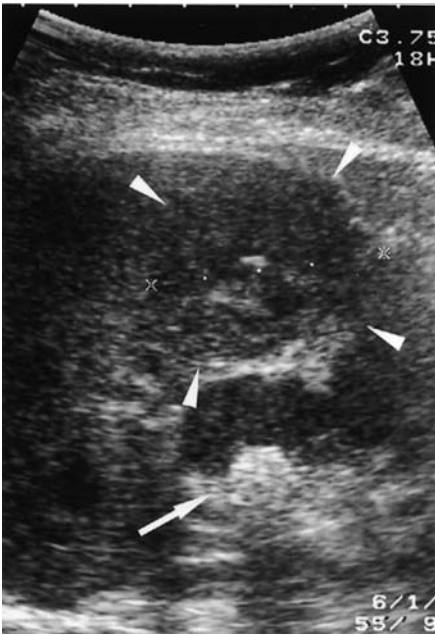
Abdominal ultrasonography (US), showing a 14-mm gallstone (*arrow*), and a heterogeneously hypoechoic mass around the gallbladder bed (*arrowheads*)
